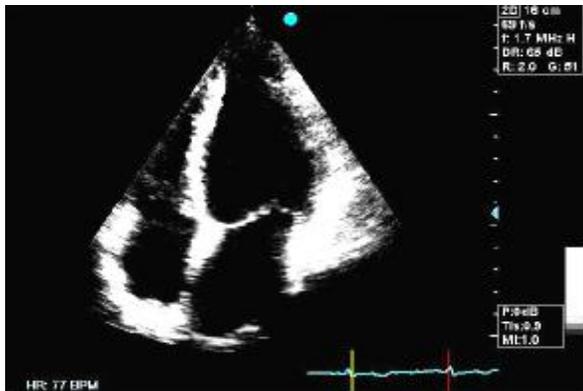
Apical four-chamber view shows mild hypertrophy of the apical portion.
